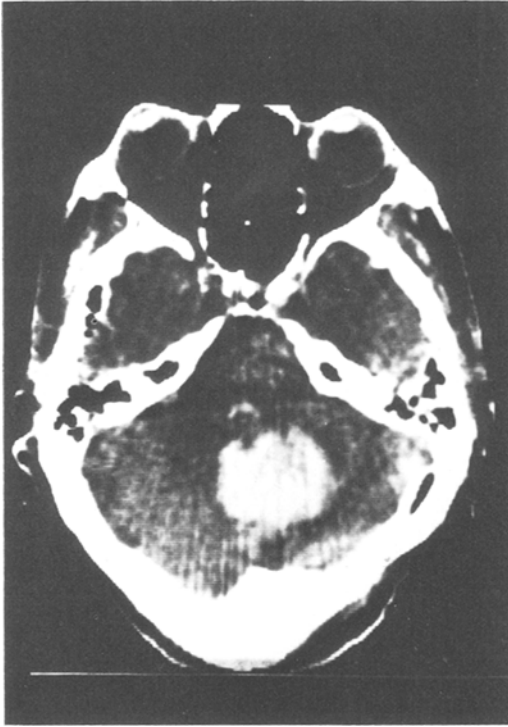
Case 1*: CT scan on admission. Large vermian and right hemispheric haemorrhage in the cerebellum
